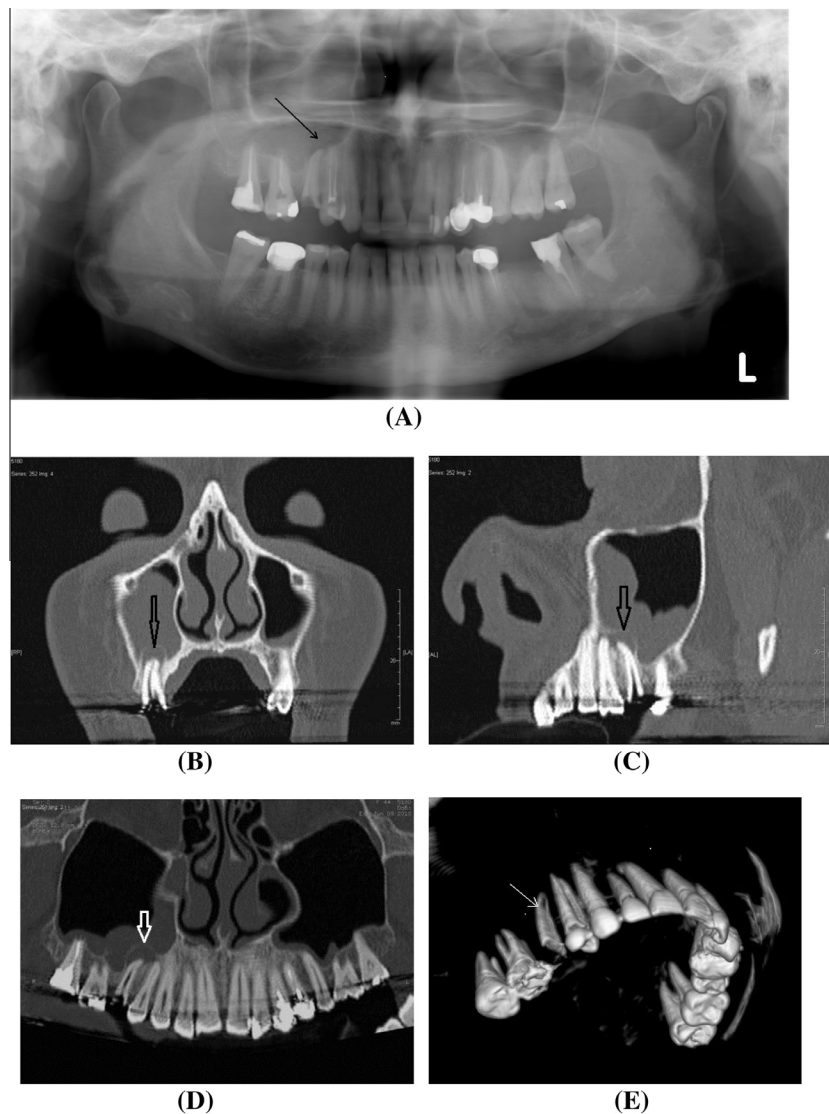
A case of broken right maxillary second premolar tooth with missing crown. Periapical abscess is seen surrounding the residual roots and showing fistulization into the maxillary antrum. (A) Digital Panorama X-ray view: the periapical abscess is adequately noted as lucency surrounding the diseased retained roots. This view failed to adequately demonstrate the bony destruction and the oro-nasal fistula. (B–D) Reconstructed MDCT images in bone windows. Coronal oblique, sagittal oblique and curved reconstruction respectively. (E and F) The retained roots are demonstrated in 3-D VR images using different angles and software. (G and H) The abscess and fistula are demonstrated in 3-D VR images using different angles. Views from inside maxillary antrum. In G the roof of the antrum was removed while the lateral wall was removed in H. (I) Virtual endoscopy, view from inside the antrum showing the abscess and fistula.
